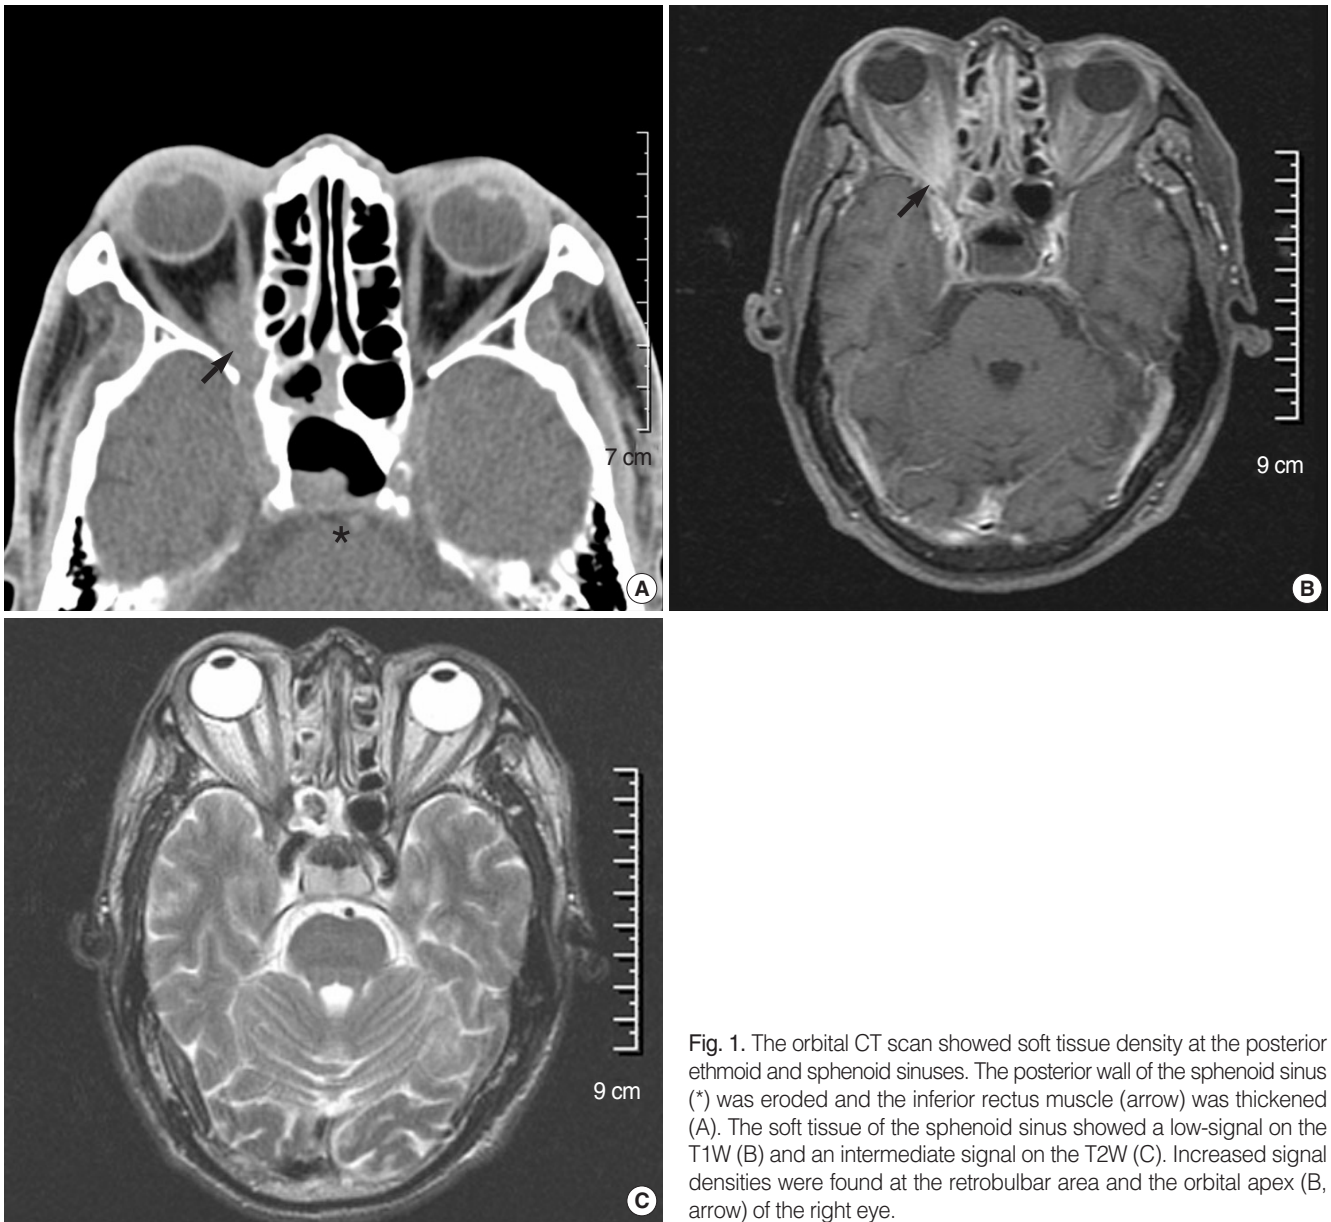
The orbital CT scan showed soft tissue density at the posterior ethmoid and sphenoid sinuses. The posterior wall of the sphenoid sinus (*) was eroded and the inferior rectus muscle (arrow) was thickened (A). The soft tissue of the sphenoid sinus showed a low-signal on the T1W (B) and an intermediate signal on the T2W (C). Increased signal densities were found at the retrobulbar area and the orbital apex (B, arrow) of the right eye.
